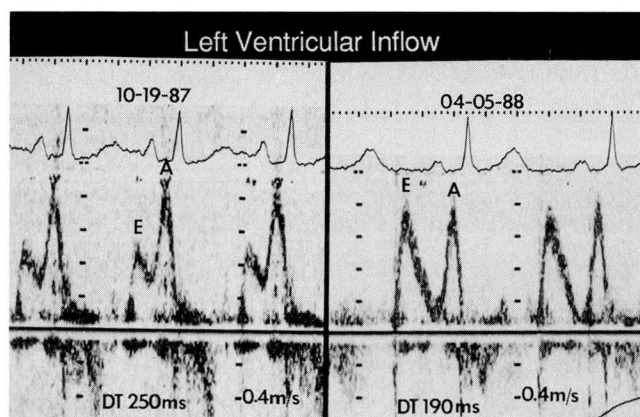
Serial left ventricular inflow patterns (pulsed-wave Doppler recordings) in a 63-year-old woman with symptomatic cardiac amyloidosis whose pattern changed from abnormal relaxation to “pseudonormalization” over 5.5 months. Left, decreased E/A ratio (0.5) and prolonged deceleration time (DT) (250 milliseconds). Right, 5.5 months later, E/A ratio (1.0) and deceleration time (190 milliseconds) are normal. (From Klein et al.¹⁰)
